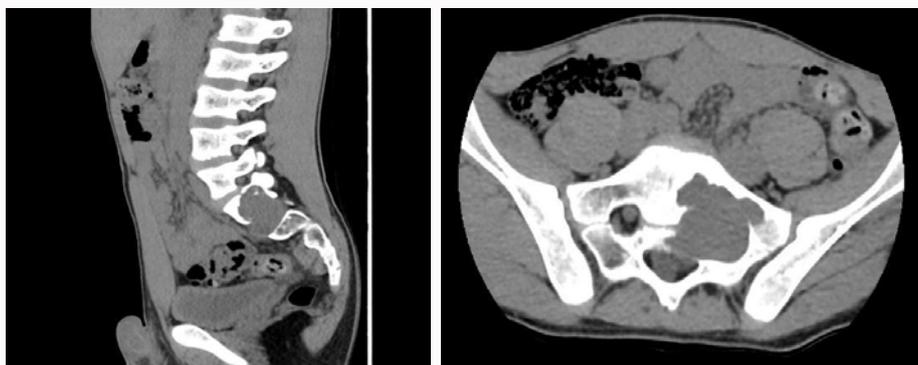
Sagittal and axial slice from lumbosacral CT where an expansive lesion affects S1 and S2 level inducing joint lysis and spreading across sacral foramen near left iliac vessels.
